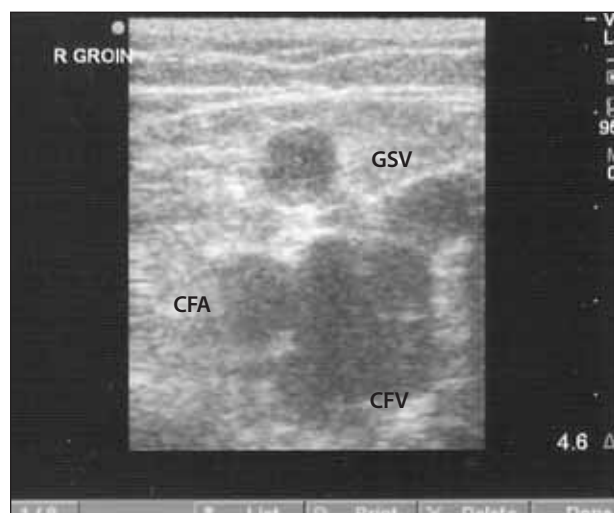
Venous duplex ultrasound of the AAGSV. This transverse image shows the anatomical relationship of the AAGSV with the surrounding vessels. The AAGSV diameter measured 8.5 mm and showed severe reflux. When present, the AAGSV is always superficial to the common femoral vein (CFV), medial to the common femoral artery (CFA), and lateral to the GSV.
